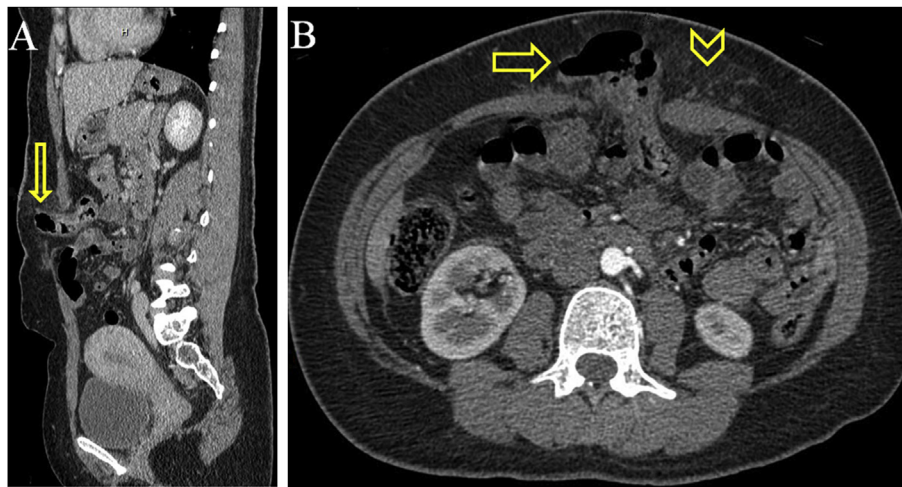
(A) CT scan (sagittal view) showing protrusion of loops of bowel through the abdominal wall defect at the skin site of bicycle handlebar injury (arrow). (B) Axial CT scan of the abdomen showing protrusion of loops of bowel through a defect along the medial fibers of the left rectus muscle (arrow). There is fat stranding corresponding to the site of skin handlebar injury (arrow head) indicating an acute event.
